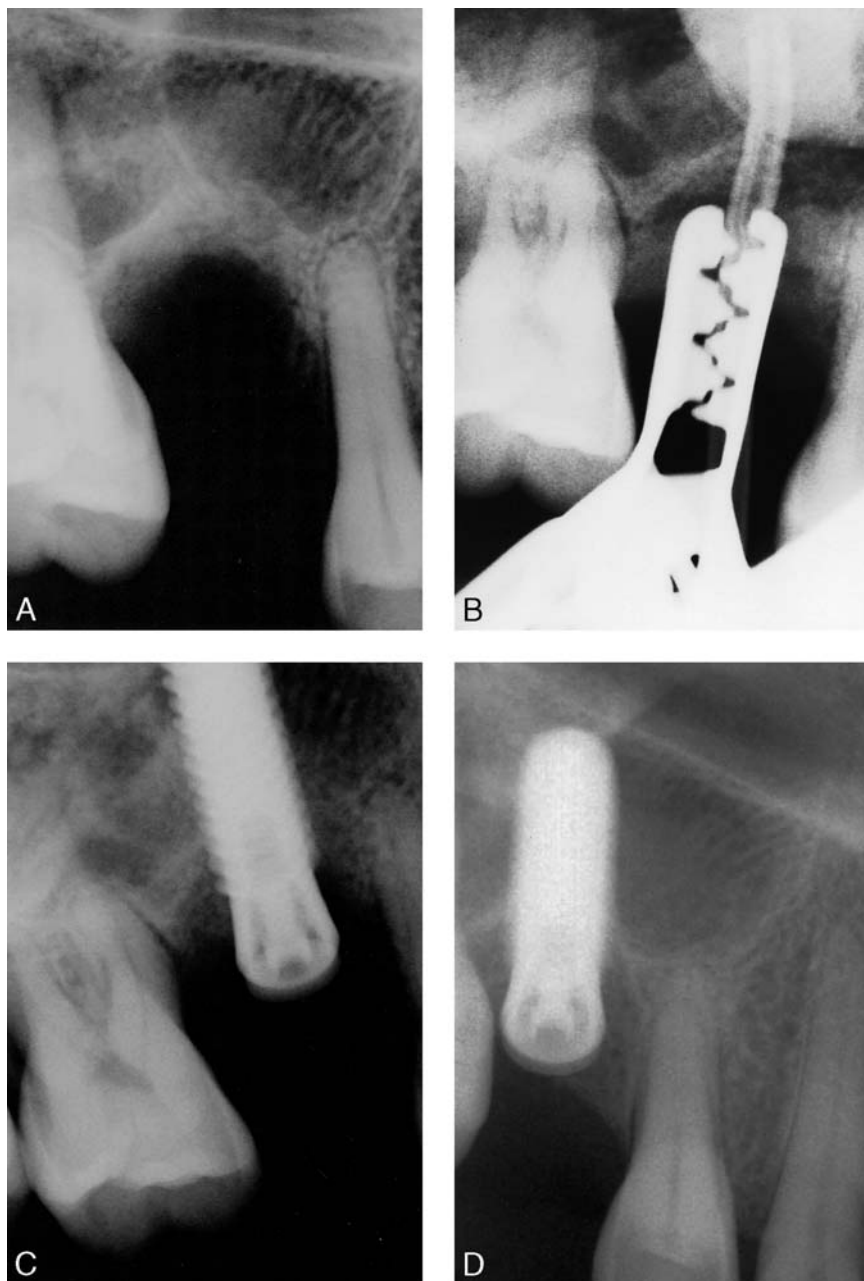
Case 7. (A) Preprocedural periapical X ray. (B) Minimally invasive antral membrane balloon elevation. (C) Implant fixation after bone transplantation. (D) Follow up (6 months).
